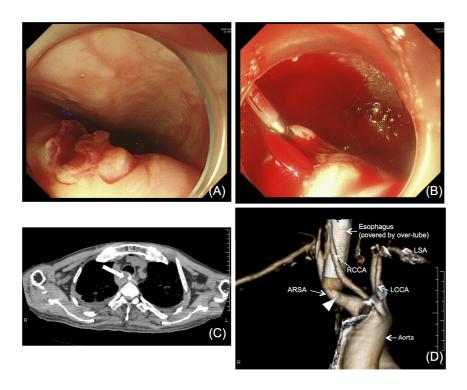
Third endoscopy of a 55-yearold febrile man with a nasogastric feeding tube (A, B) revealed massive blowout bleeding from the lesion was initially considered an over-tube injury during previous examinations. Postmortem computed tomography carried out on autopsy (C) revealed an endoscopic clip located adjacent to the aberrant right subclavian artery (ARSA) (arrow). An arterial bleb (arrowhead) in contact with the esophagus was revealed by reconstruction of computed tomography images on admission (D). LCCA, light common carotid artery; LSA, left subclavian artery; RCCA, right common carotid artery.
